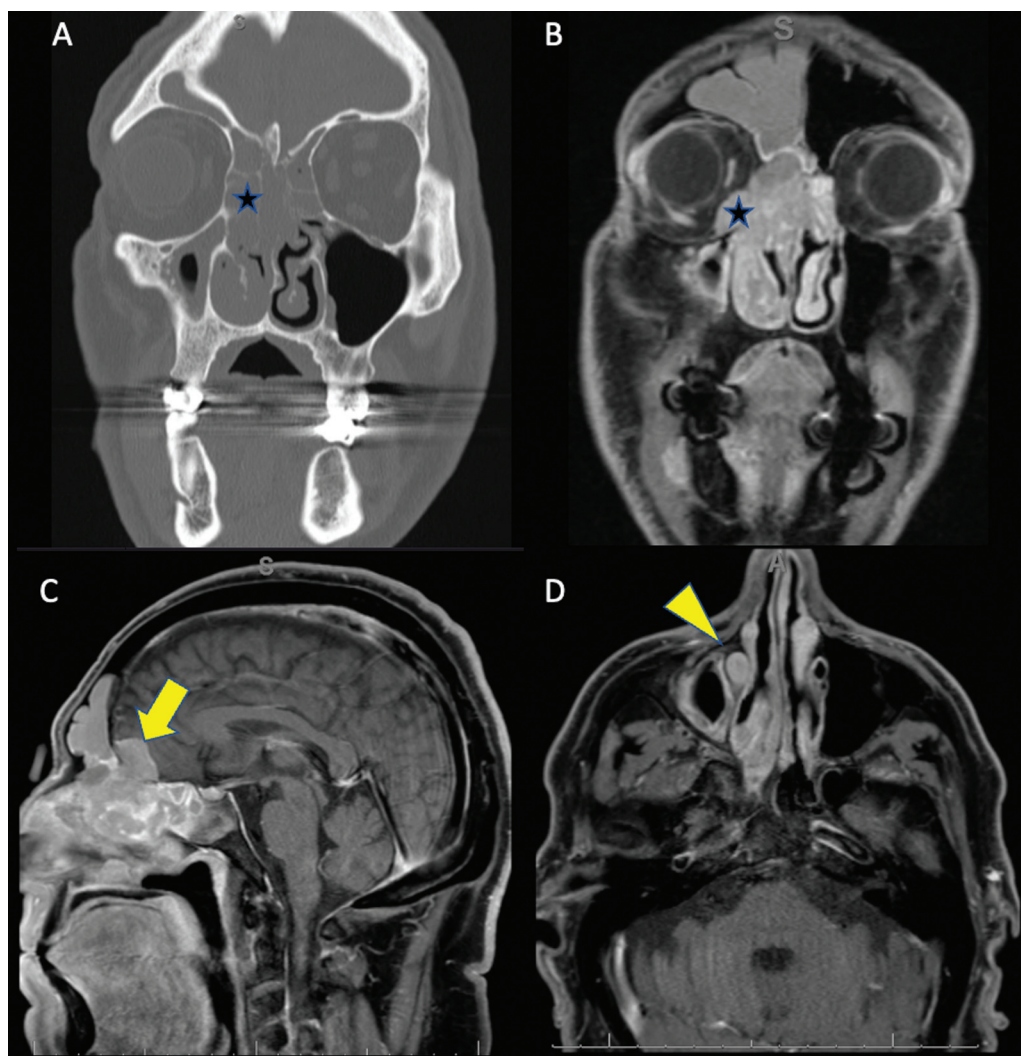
Preoperative computed tomography (CT) (A) and magnetic resonance imaging (MRI) (B–D) images of right sinonasal mass with intraorbital extension (star), anterior cranial fossa extension (arrow), and nasolacrimal duct involvement (arrowhead).
